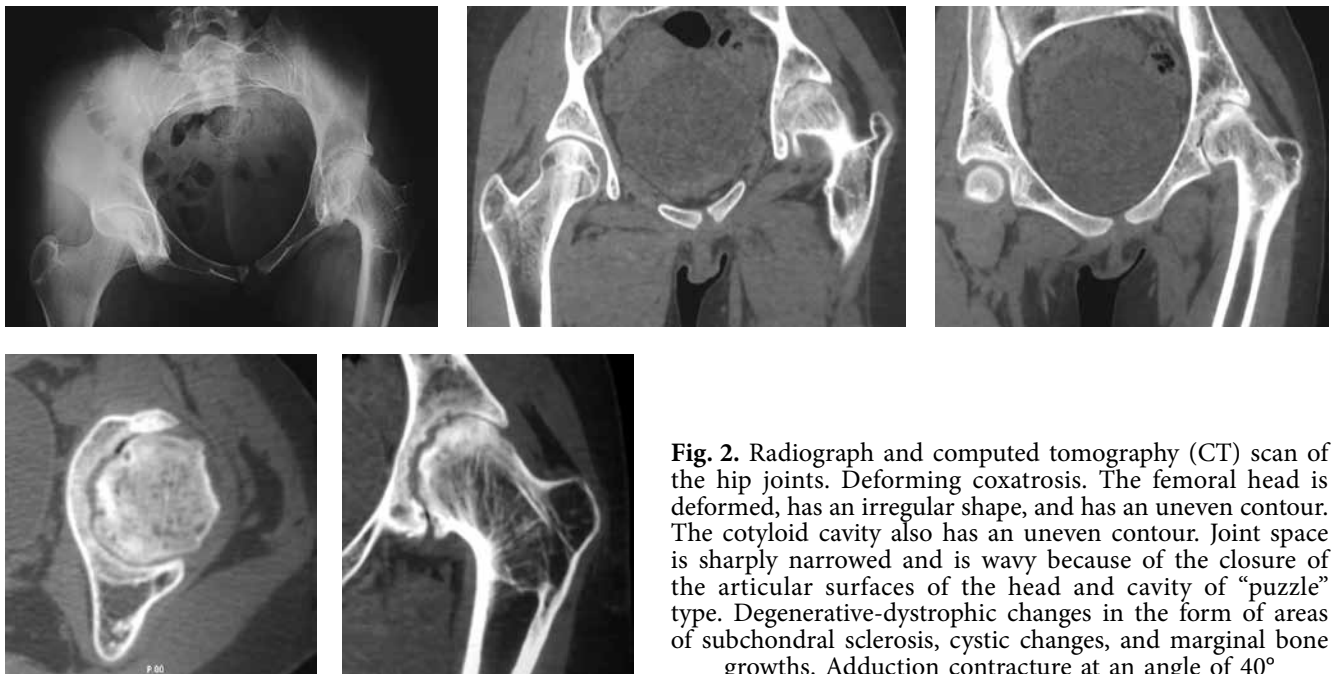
Radiograph and computed tomography (CT) scan of the hip joints. Deforming coxatrosis. The femoral head is deformed, has an irregular shape, and has an uneven contour. The cotyloid cavity also has an uneven contour. Joint space is sharply narrowed and is wavy because of the closure of the articular surfaces of the head and cavity of “puzzle” type. Degenerative-dystrophic changes in the form of areas of subchondral sclerosis, cystic changes, and marginal bone growths. Adduction contracture at an angle of 40°
